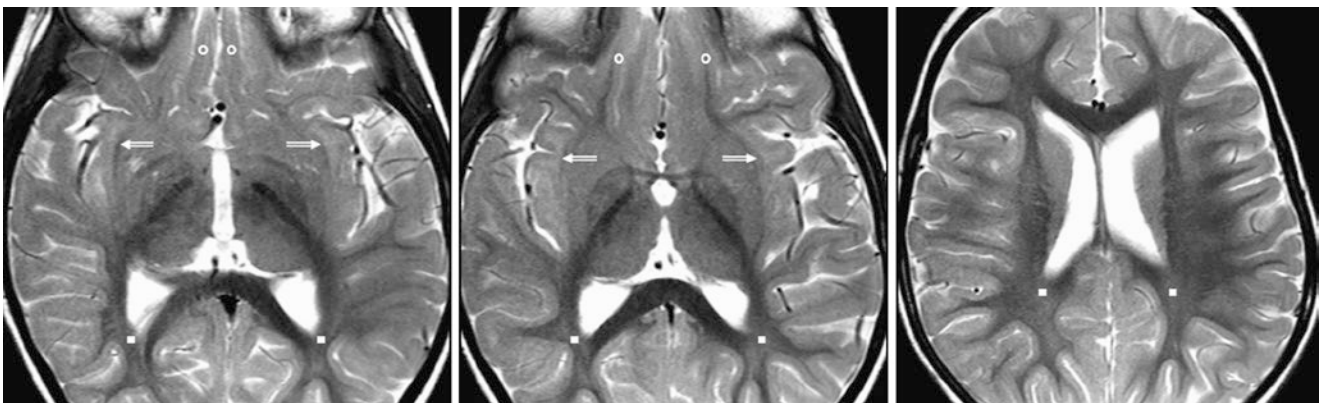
A 2.75-year-old with cerebellar symptoms had a normal 3T MRI. On SE T2WIs, note hyperintense, residual terminal zones within the SIWM (*beveled arrows*), whereas the OFWM (*circles*)
